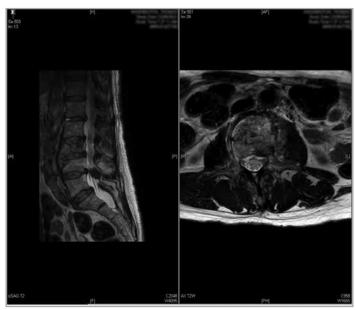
Represents follow up imaging with MRI (T2-weighted sagittal and axial views) without contrast completed 3 months after initial x-ray that showed a stable L3 vertebral compression fracture involving both the anterior and posterior cortex as well as high-grade neuroforaminal stenosis at L3-L4 on the left side.
